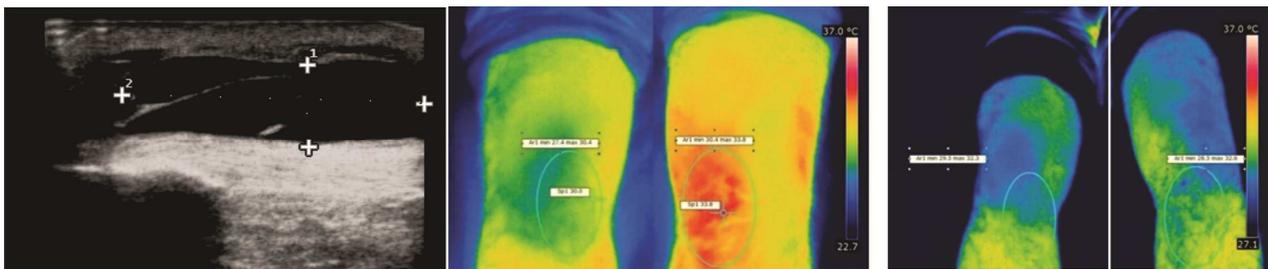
Prepatellar bursitis ultrasound and thermography before and after treatment (decrease of  $\Delta T$  from  $3,8^{\circ}\text{C}$  to  $0,3^{\circ}\text{C}$ )
